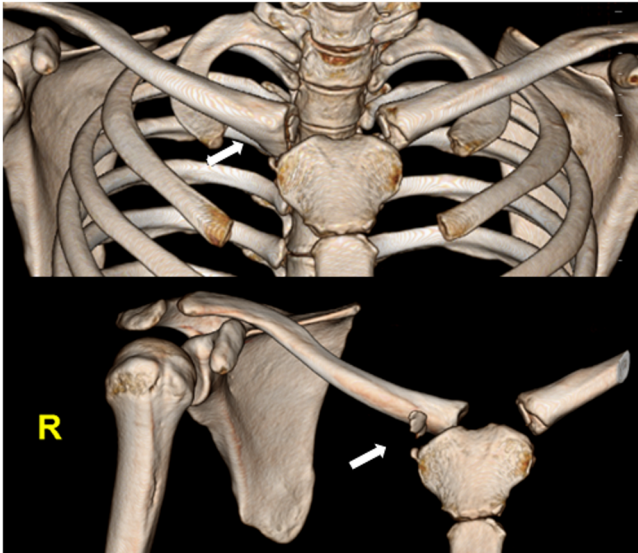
Three-dimensional computed tomography images showing dislocation of the right sternoclavicular joint and medial epiphyseal separation of the right clavicle.
